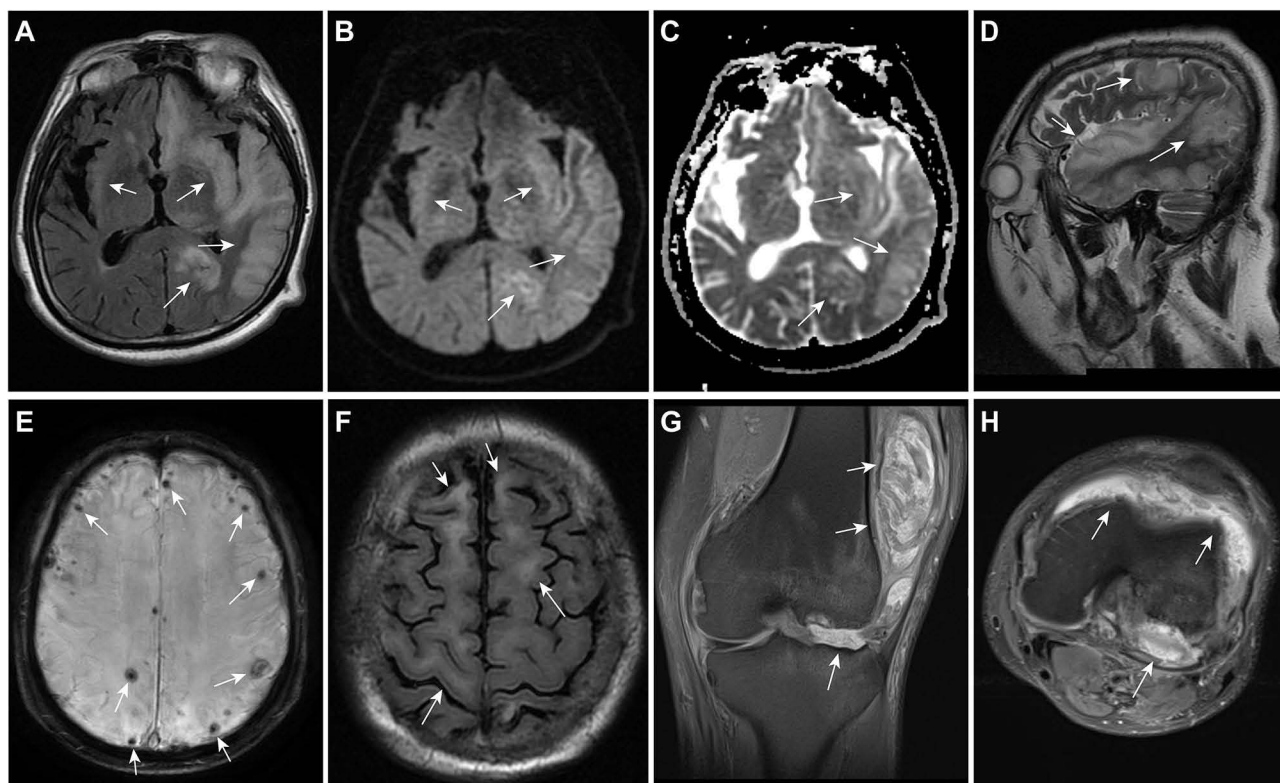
(A–D) In a 48-year-old male patient with syphilitic meningoencephalitis, the axial FLAIR-weighted image (A) and the sagittal T2-weighted image (D) showed diffuse hyperintensity and swelling in the bilateral cerebral cortex and subcortical areas, more pronounced on the left side (arrows). The corresponding areas on the axial DWI sequence (B) showed slightly increased signal intensity, while the ADC map (C) showed increased signal intensity (arrows). (E and F) In a 60-year-old male patient with general paresis, the SWI sequence (E) showed multiple microhemorrhages beneath the cortical surface (arrows), and the FLAIR image (F) showed multifocal white matter abnormal signals and brain atrophy (arrows). (G and H) In a 43-year-old male patient, the coronal (G) and axial (H) sections of the left knee on MRI revealed articular destruction, with irregularity of articular surface and intra-articular effusion (arrows).
